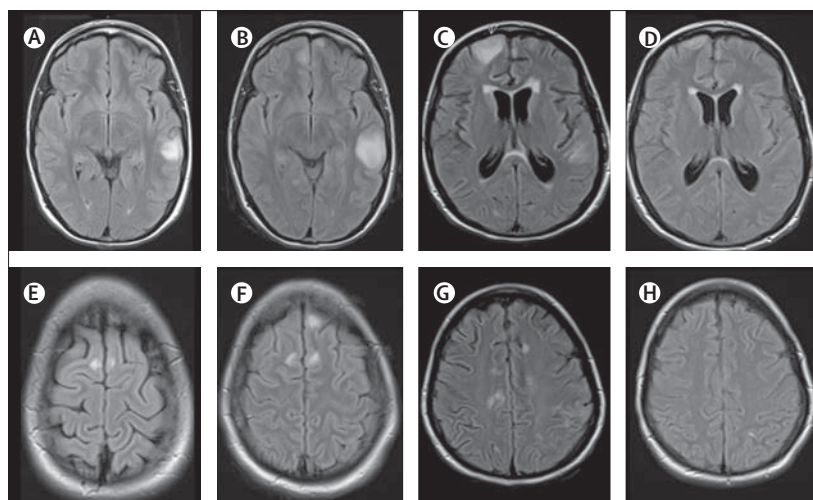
MRI findings in index patient 1
